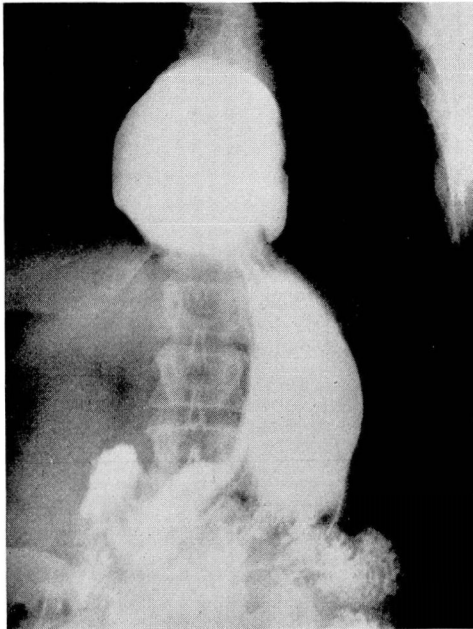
Large para-esophageal hiatus hernia in 60 year old white man treated on numerous occasions for severe secondary anemia now believed due to occult bleeding from herniated stomach. Anemia totally corrected following transthoracic repair of hiatus hernia.
